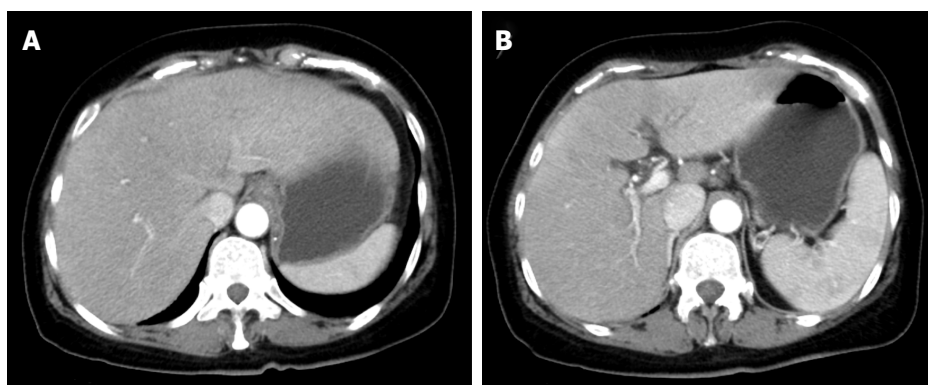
Contrast computerized tomography before the treatment. A: CT revealed hepatomegaly with no mass or dilatation of the intrahepatic duct in the liver; B: CT revealed splenomegaly. CT: Computerized tomography.
